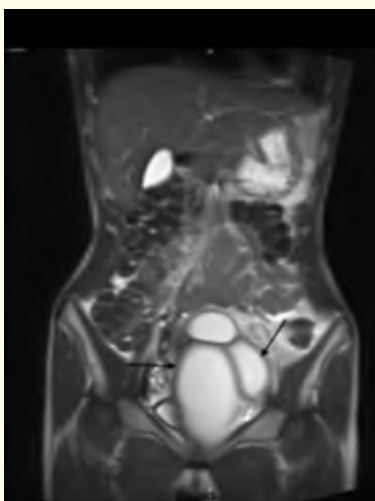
MRI: Coronal T2WI shows dilated vagina, cervix and left uterine horn with high signal intensity blood (arrows).*
